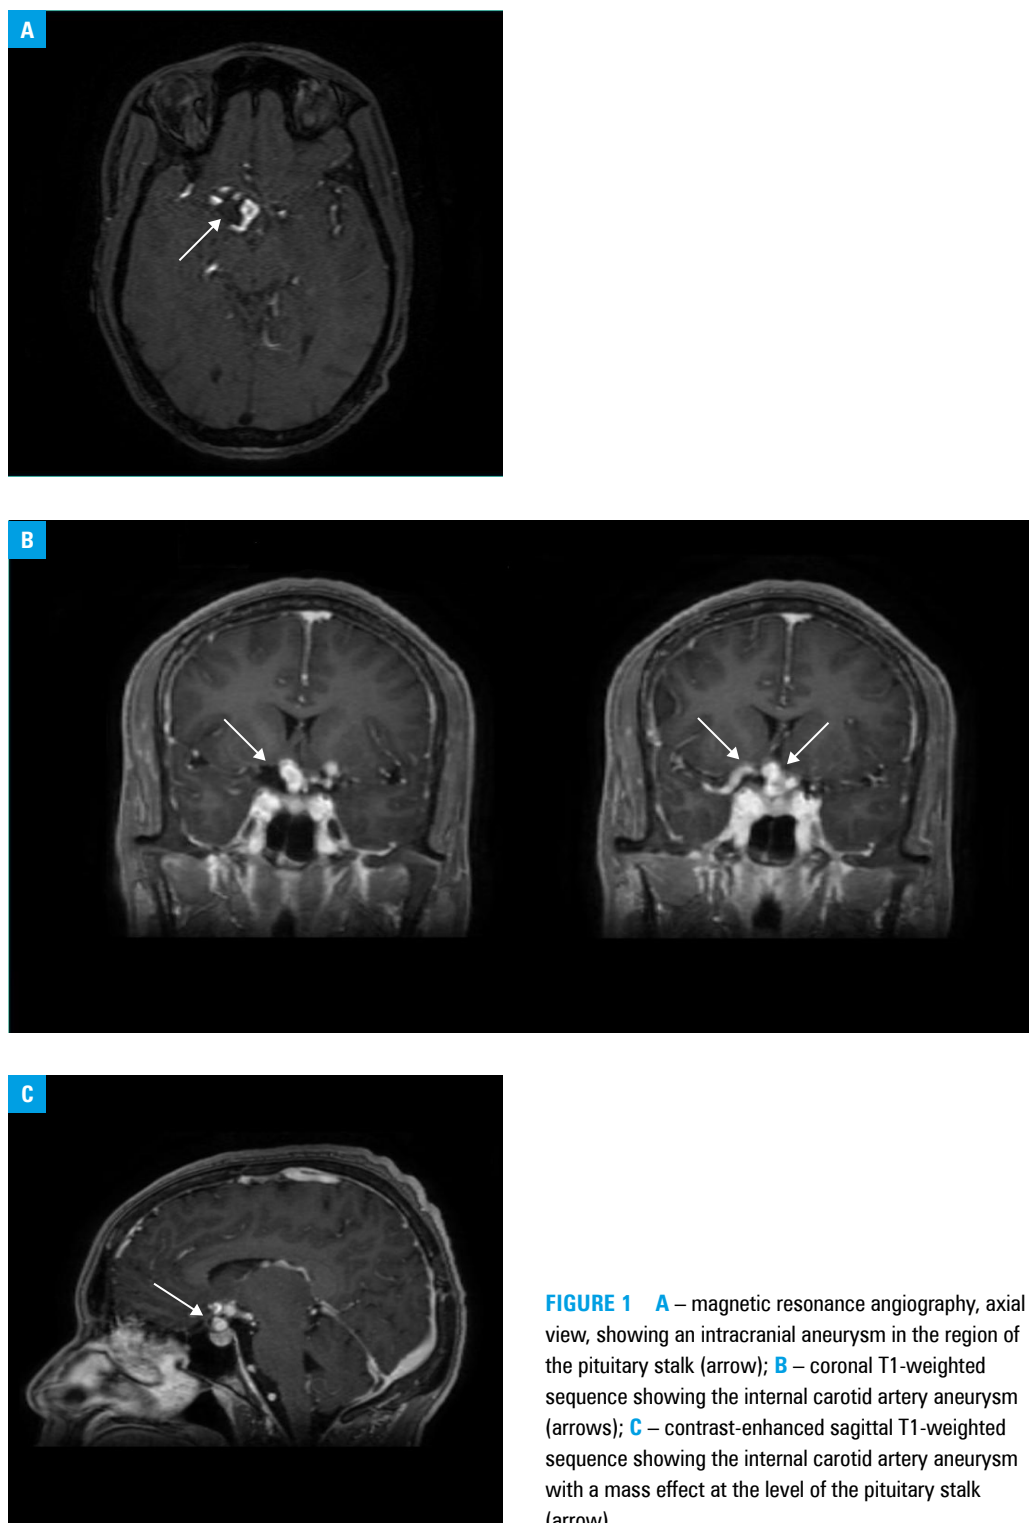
A – magnetic resonance angiography, axial view, showing an intracranial aneurysm in the region of the pituitary stalk (arrow); B – coronal T1-weighted sequence showing the internal carotid artery aneurysm (arrows); C – contrast-enhanced sagittal T1-weighted sequence showing the internal carotid artery aneurysm with a mass effect at the level of the pituitary stalk (arrow)
